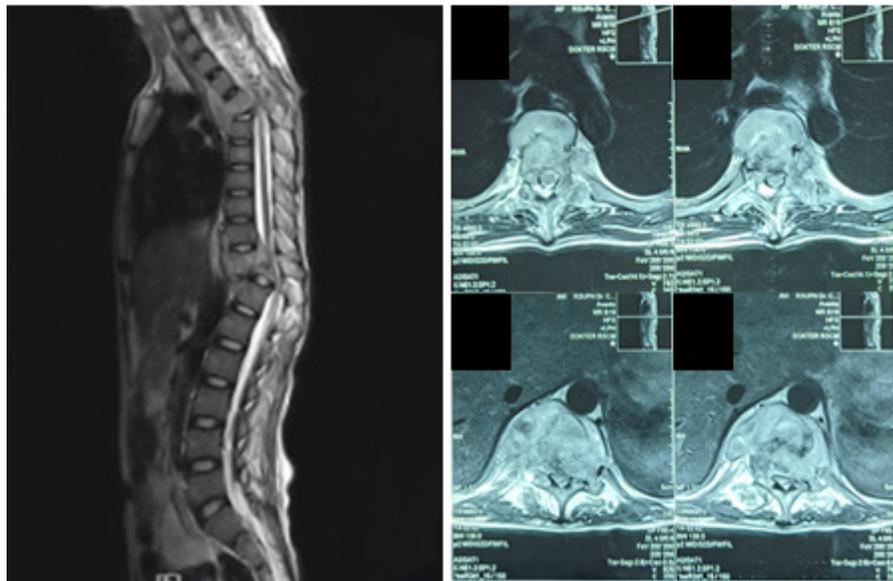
Spinal MRI results: (a) axial T2WI MRI showing paravertebral abscess formation and nerve compression; (b) sagittal T2WI MRI depicting two compression sites (red arrows).
